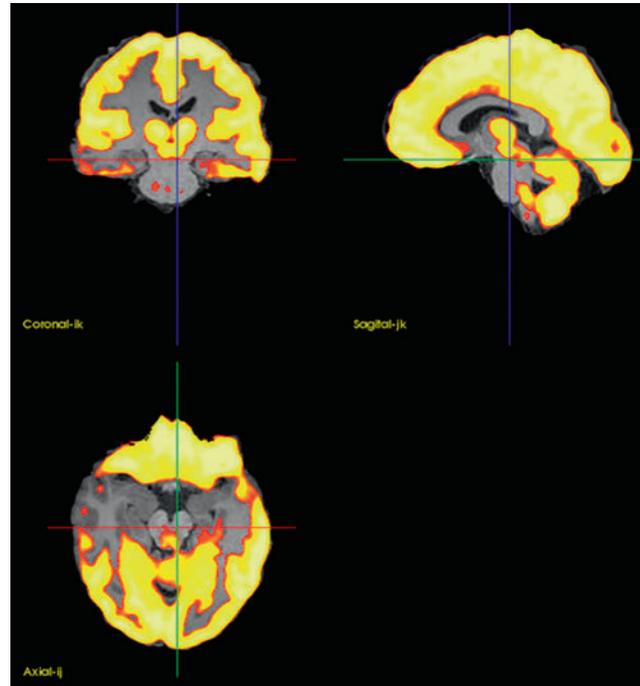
The medial temporal hypometabolism on the positron emission tomographic (PET) scan (color scale) is superimposed on the magnetic resonance image. This co-registration aids in localization of the abnormality.
